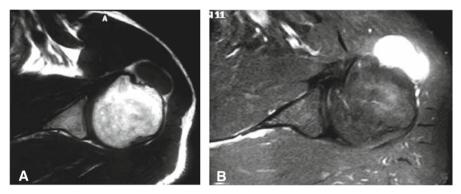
Schwannoma of the left shoulder (sensory nerve): T1 weighted MRI without (A) and with (B) gadolinium enhancement
